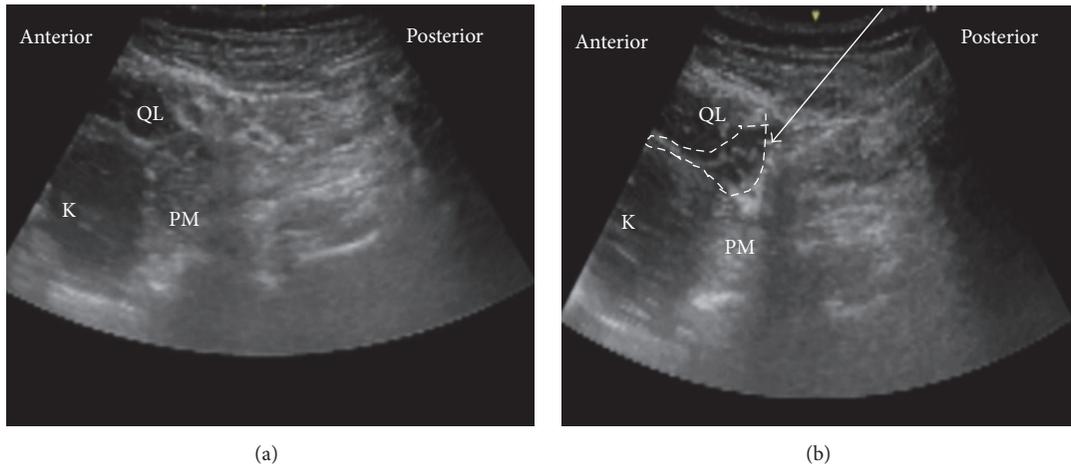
Ultrasound images of subcostal QL block. (a) Preinjection and (b) postinjection. QL: quadratus lumborum, PM: psoas muscle, white arrow: needle trajectory, and white dotted line: spread of local anesthetic.
